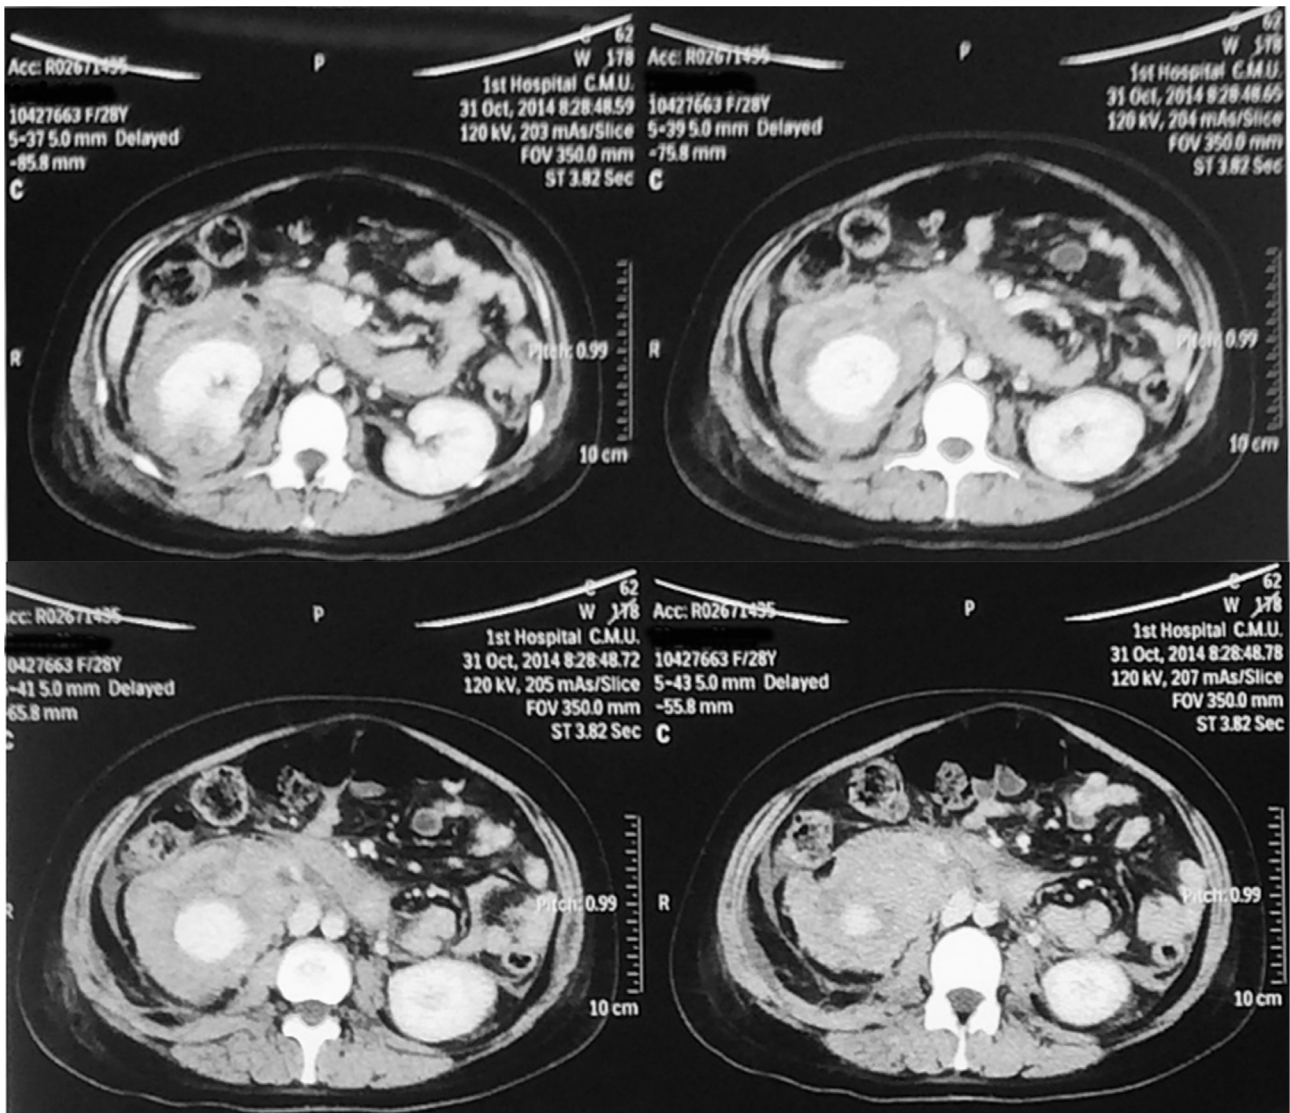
Computed tomography image showing a hematoma around the right kidney.
